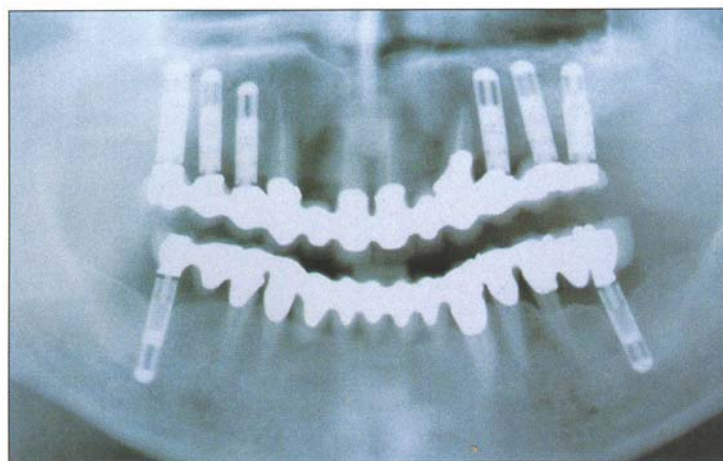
Panoramic radiograph of the implant-supported restoration (definitive ceramometal fixed prostheses) in the mandible and maxilla, 4 years postoperatively.
